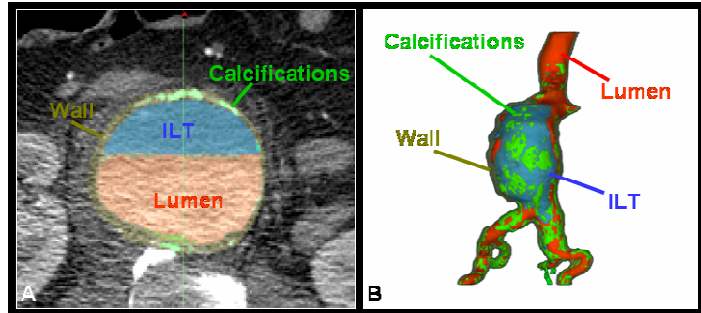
Three dimensional image reconstruction from patient CT data is performed in Mimics using masks for each two-dimensional image slice. (A) Masks are shown in a two dimensional CT image slice. The outer wall is shown in yellow, ILT in blue, calcifications in green, and lumen in red. (B) Three-dimensional rendering of the pathological ruptured structure is performed with further iterative smoothing techniques for each one of the segmented surfaces.
